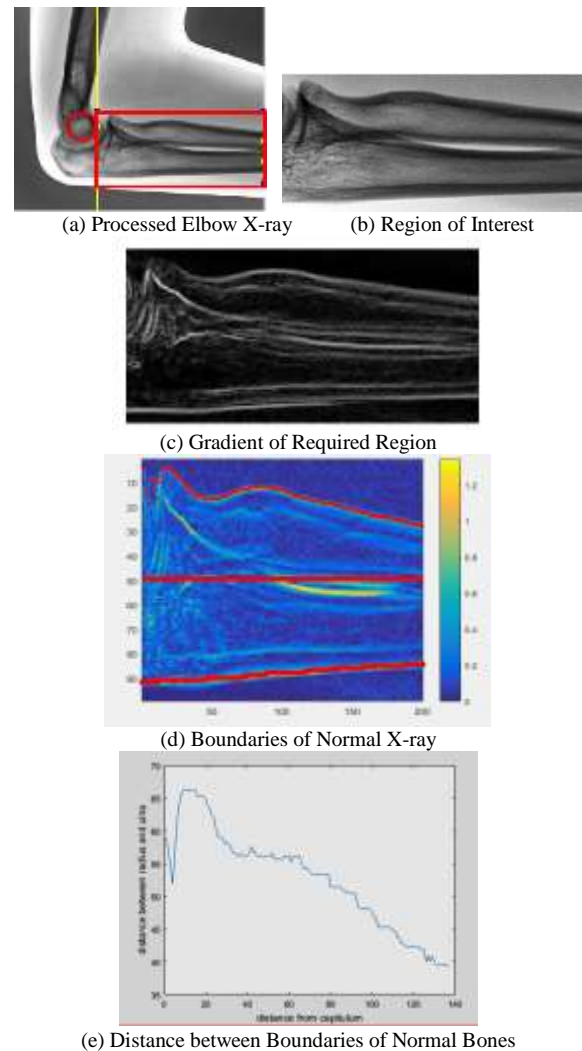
Geometrical Shape of Normal Bone. (a) Shows the Processed Elbow X-ray to get the Required Region. (b) Shows the Required Region to Detect the Abnormality in Bones. (c) Shows the Output of Image Gradient. (d) Shows the Colored Version of Gradient Output with Boundaries of Normal Bones. (e) Indicates the Distance between Normal Radius and Ulna Bone.
